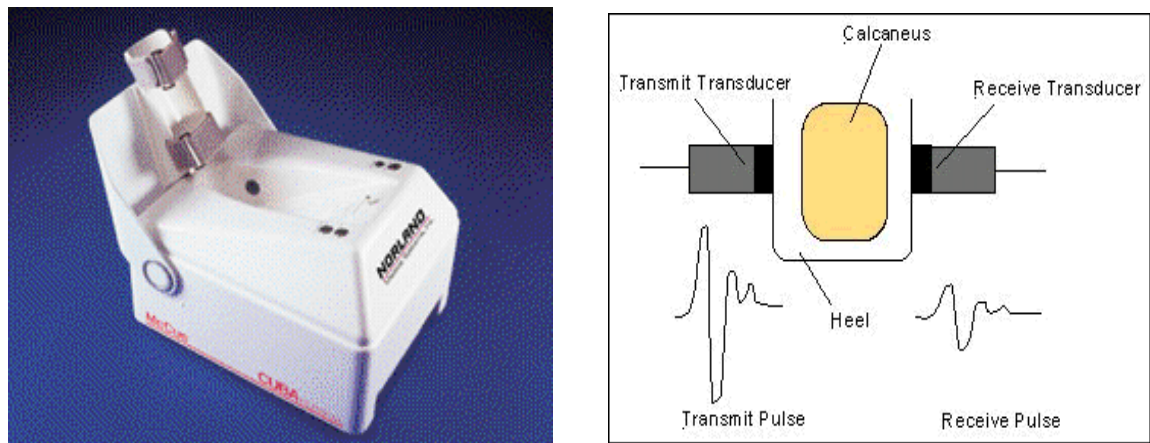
Calcaneal Ultrasound
